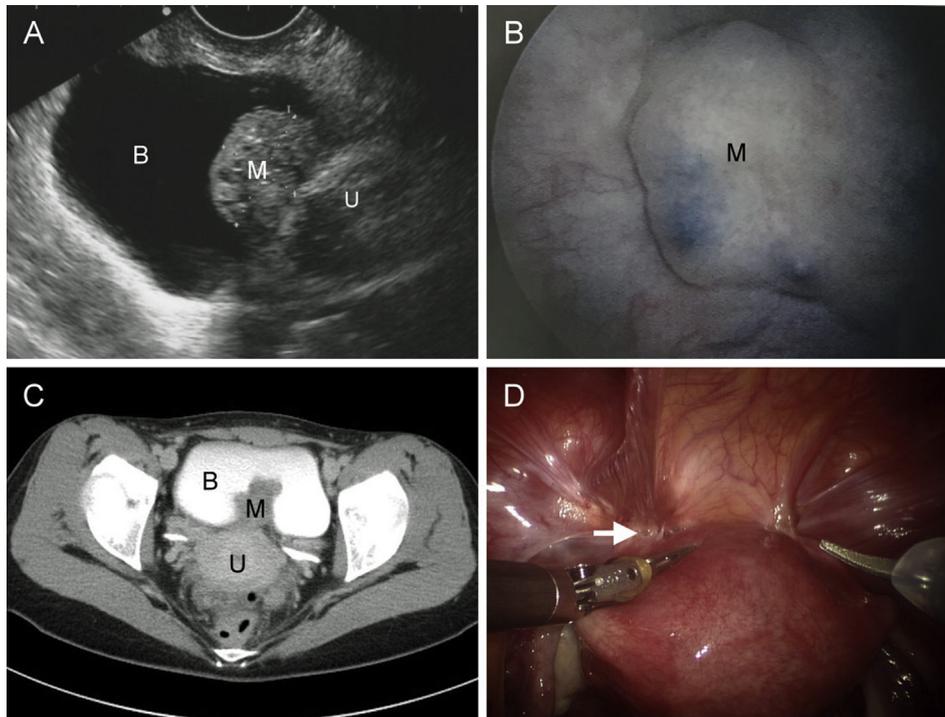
(A) Transvaginal ultrasound showed a heteroechoic mass lesion (M) in the bladder (B). (B) A bladder mass (M) on the bladder wall was found by cystoscopy. (C) Pelvic computed tomography showed a lobulated tumor (M) in the posterior wall of urinary bladder (B) abutting to the anterior wall of the uterus (U). (D) Laparoscopy revealed extensive deep infiltrating endometriosis with obliterated uterovesical fold (white arrow).
